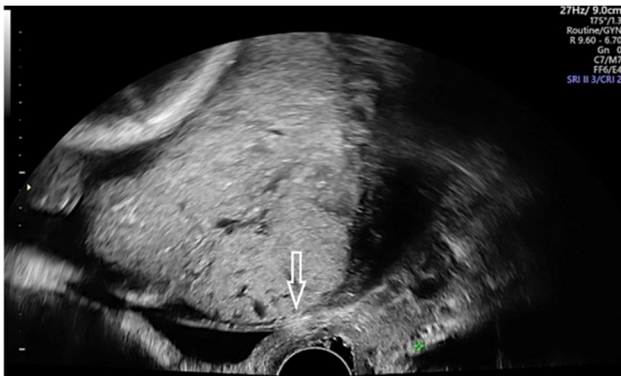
Transvaginal sonogram: retroplacental clear zone (white arrow) in pregnant woman, 36 years old, 37 GW, obstetrical history: four uterine Cesarean scars, the last for placenta praevia associated with placenta increta. GW: Gestational weeks.
